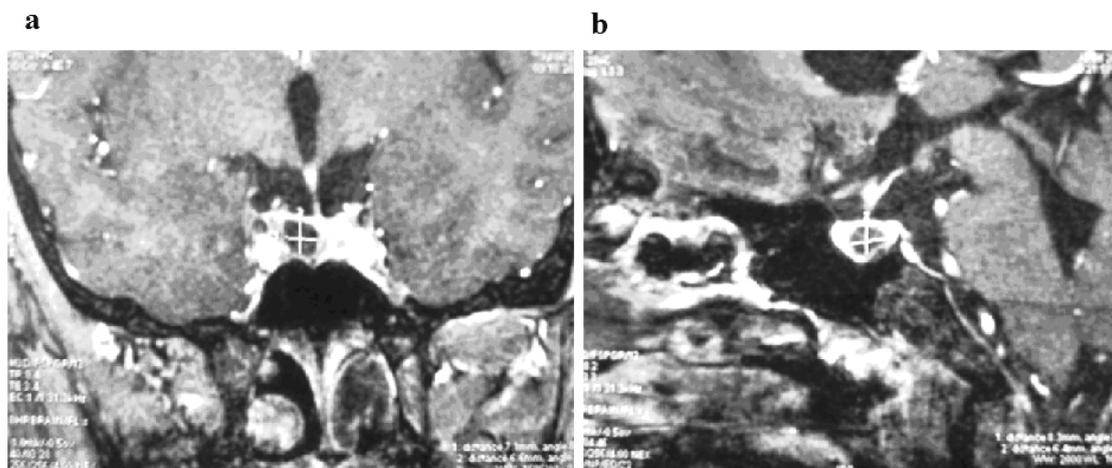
Magnetic resonance imaging (MRI) pituitary scans with a hypodense intrasellar tumor on the right side of the fossa suggesting pituitary adenoma (a – coronal section; b –sagittal section)
